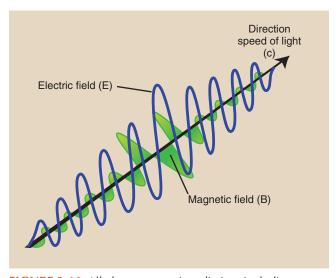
All electromagnetic radiation, including x-rays, can be visualized as two perpendicular sine waves that travel in a straight line at the speed of light. One of the sine waves represents an electric field and the other a magnetic field.
